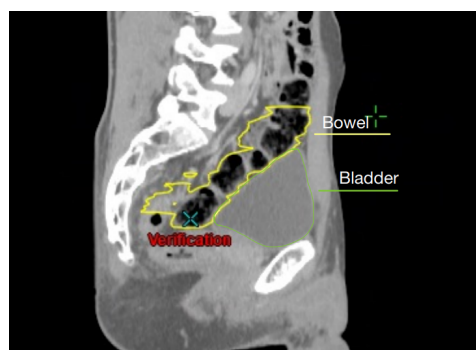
CT scan of a male patient
